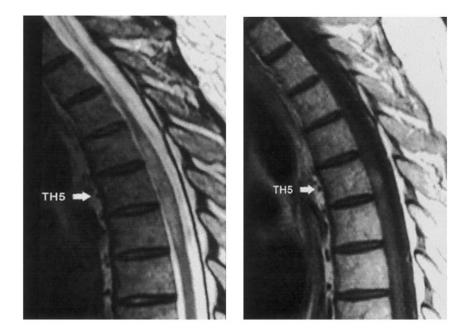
Spinal MRI scan, March 1998. *Left panel*, Sagittal T2-weighted fast spin echo sequence: localized (TH4–TH6) increase in cord caliber containing a heterogenous zone of high signal intensity. *Right panel*, Sagittal T1-weighted fast spin echo sequence after gadolinium chelate injection: nodular contrast enhancement in the cord at the level of the fifth thoracic vertebra.
